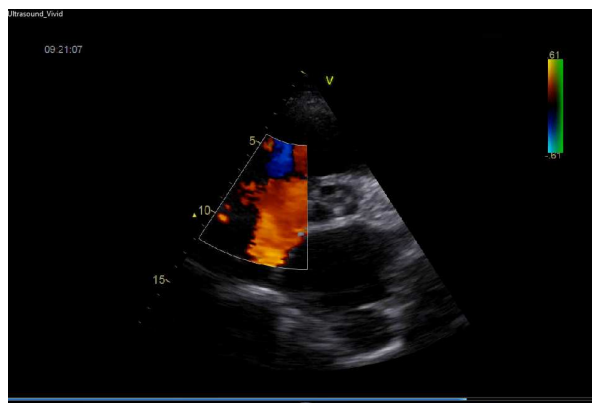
Backflow on the tricuspid valve. Color Doppler mapping - A4C, Color Doppler
